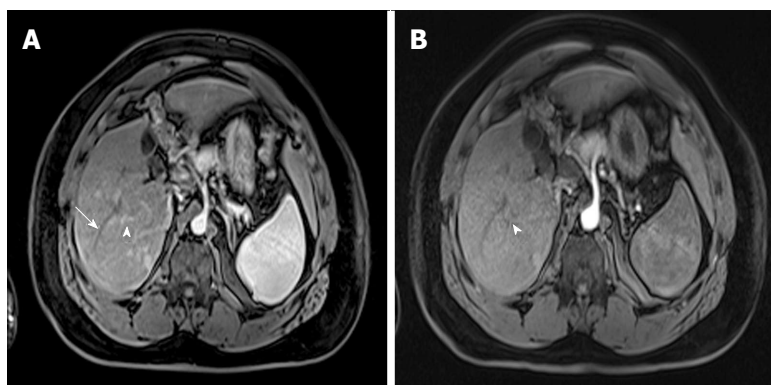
Value of proper timing for detecting hypervascular hepatic lesions. A-B: Post-contrast fat-suppressed 3D-GRE T1-weighted images acquired 4 mo apart. A: Initial scanning shows contrast in the portal vein branches (arrowhead, A), without opacification of the hepatic veins (arrow, A), suggesting late hepatic arterial phase timing; the optimal time for detecting hypervascular pathologies, with demonstration of multiple lesions; B: A subsequent scan acquired 4 mo later shows contrast in the hepatic artery without opacification of the portal vein branches (arrowhead, B), suggesting an early arterial timing, without evidence of hypervascular lesions. A subsequent scan was acquired (not shown); which confirmed the persistence of these hypervascular lesions. GRE: Gradient recalled echo.
